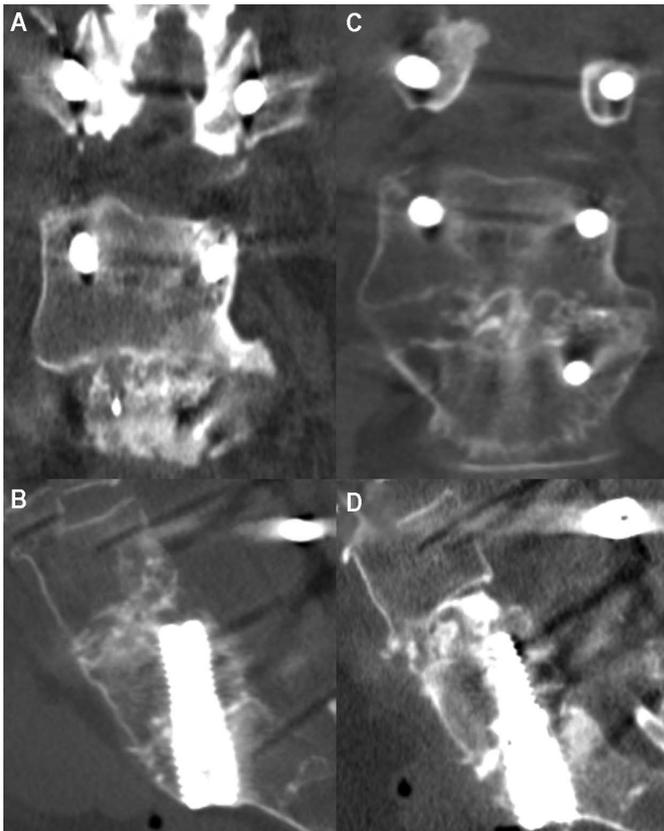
Example of transforaminal lumbar interbody fusion (at L4–L5 level). (A and B) Coronal and sagittal computed tomographic (CT) scans of a 71-year-old woman, immediate postoperation. (C and D) Coronal and sagittal CT scans of the same patient, 1 year after the procedure.
